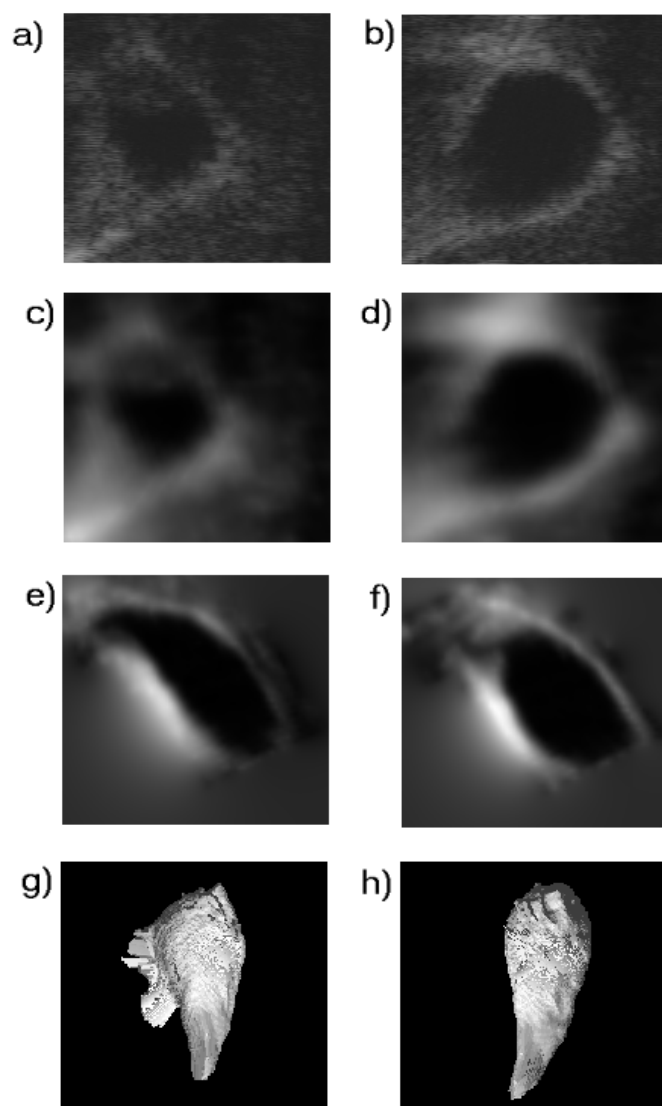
a-b) ultrasound images of a gall bladder, c-d) reconstructed planes; e-f) new planes of the reconstructed volume, g-h) 3D reconstruction of the gall bladder
